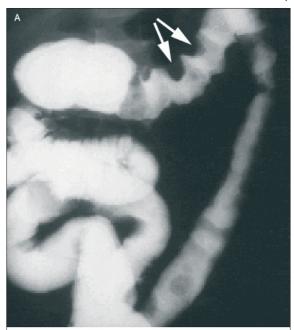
Radiographic features of E coli O157:H7 infection
